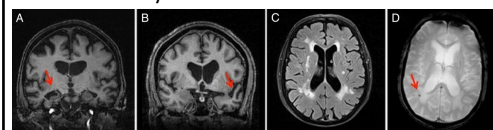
Four axial MRI scans (A, B, C, D) showing different levels of cognitive impairment. A shows a normal brain, B shows mild impairment, C shows moderate impairment, and D shows severe impairment.
